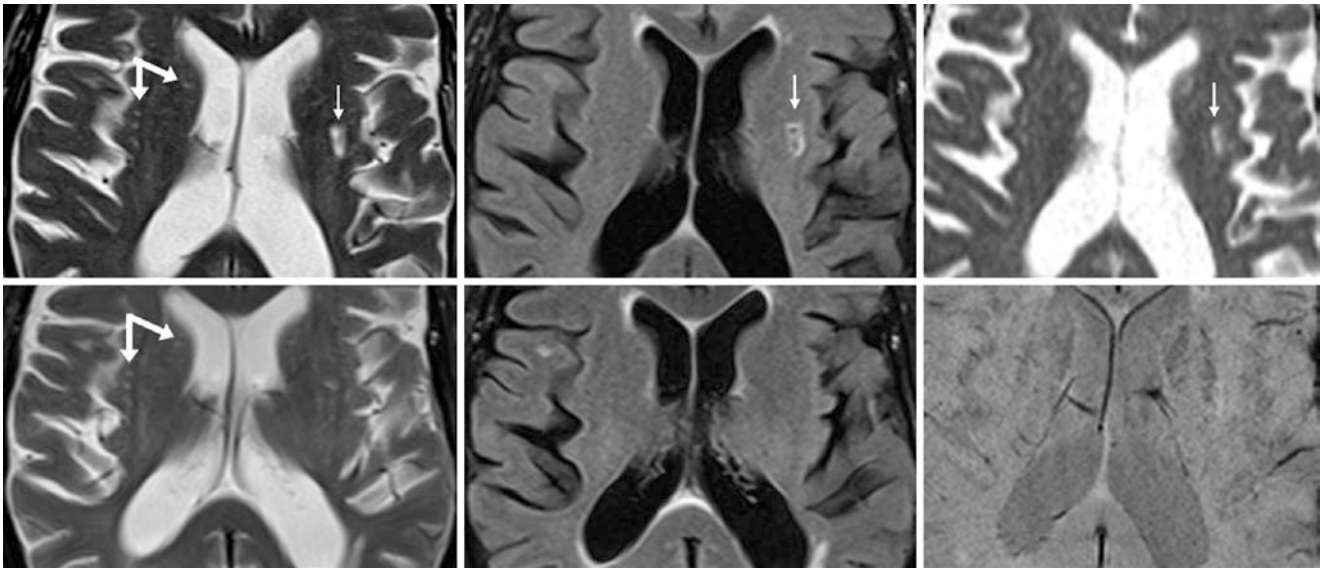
Comparison case of lacunar infarct. A 51 year old had a small left putaminal lesion (*thin arrows*) on 1.5T MRI T2WI (*top left*) that was bright on FLAIR (*top middle*) and ADC map (*top right*). It was
